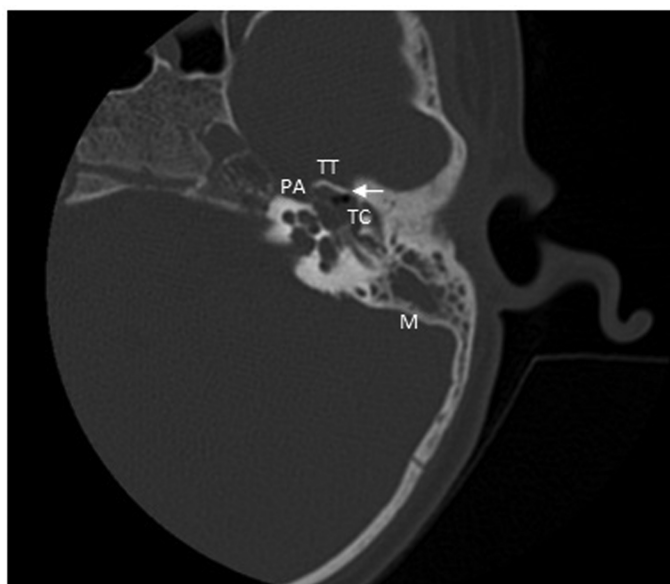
Preoperative high-resolution computed tomogram of the left temporal bone showing nonenhancing soft tissue density in the tympanic cavity (TC) with air-fluid level (arrow) and erosions of tegmen tympani (TT) and petrous apex (PA).
